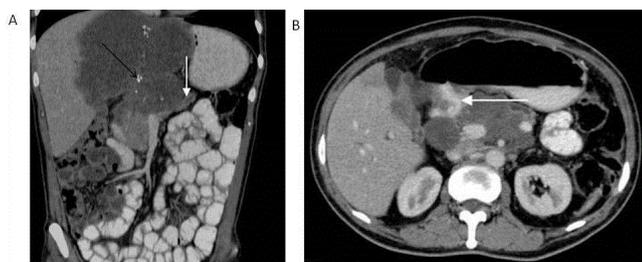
Biphasic contrast enhanced CT of the abdomen. (A) Venous phase coronal reformatted image showing ill-defined hypodense mass lesion involving the head and body of pancreas with distal atrophy of the pancreas and dilated main pancreatic duct (white arrow). The lesion in the liver is also showing multiple foci of calcification (black arrow). (B) Venous phase axial image the mass lesion with loss of fat planes with the pylorus of stomach (white arrow).
